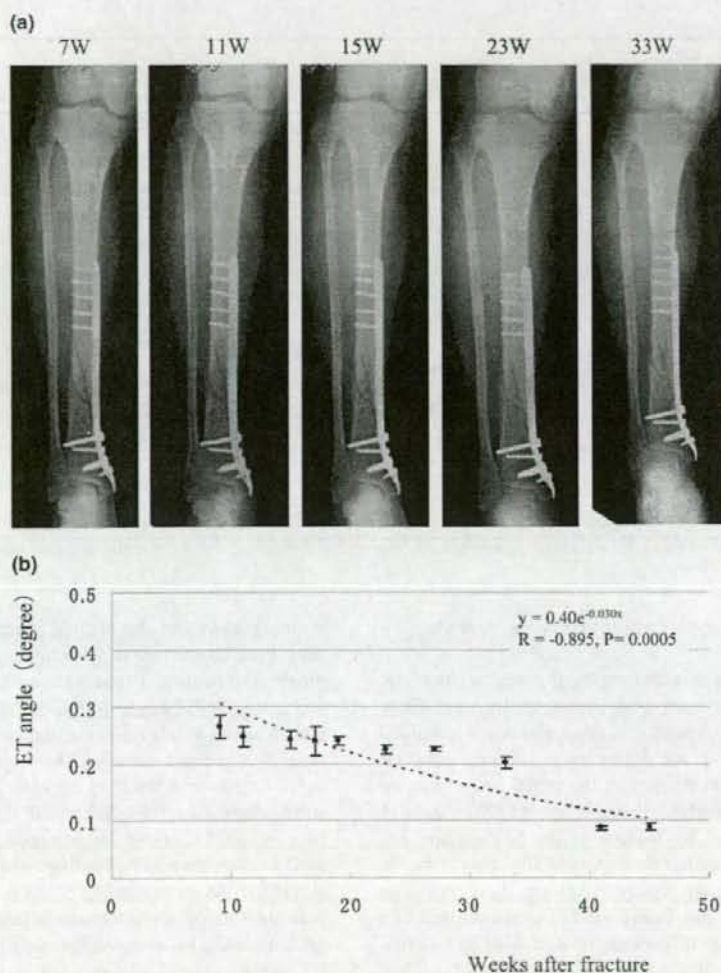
(a) The X-ray films of case 8, treated with plating. No change of the fracture site or callus was recognized on X-ray films. (b) The ET method measured the bending angle of the plate. The change was very slow, but the angle decreased significantly from 0.28 to 0.2°, and then finally declined to 0.1°.
